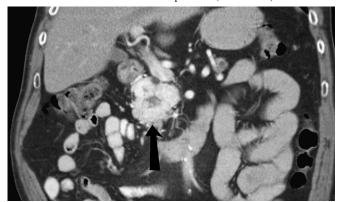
A 67-year-old man with a history of nephrectomy for renal cell carcinoma 13 years earlier. Arterial phase of contrast-enhanced computed tomography shows avidly enhancing mass, consistent with renal cell carcinoma metastasis in head of pancreas (black arrow) on the coronal reformatted image.
